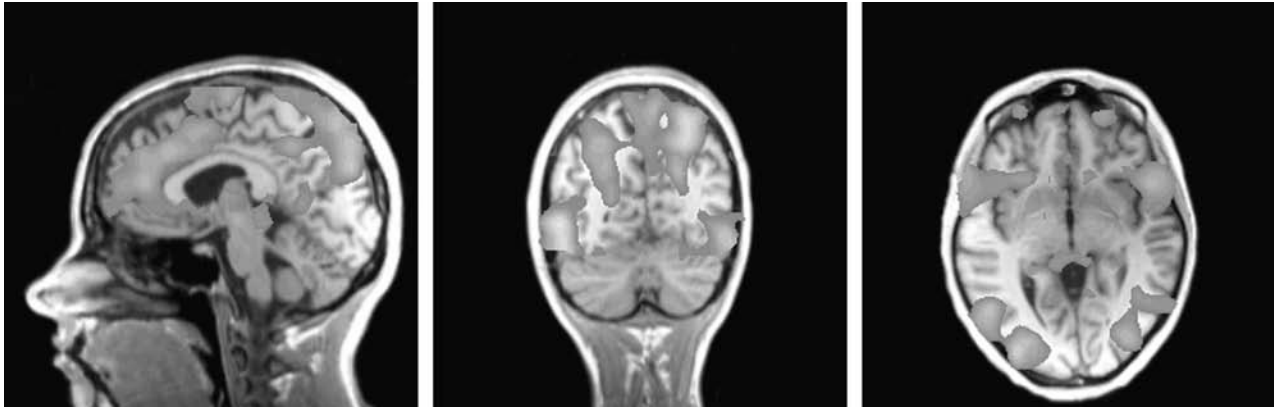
OCD-related functional MRI activation of the patient at the beginning of the therapy (OCD-related pictures minus neutral pictures; $x=4, y=-62, z=-3$; $P(\text{uncor}) < 0.001$).
